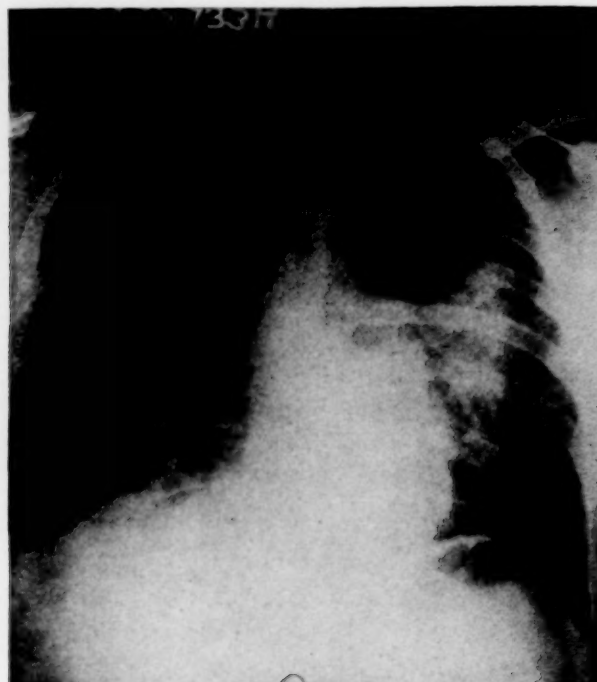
X-ray taken at the height of the radiation reaction, Case III.
